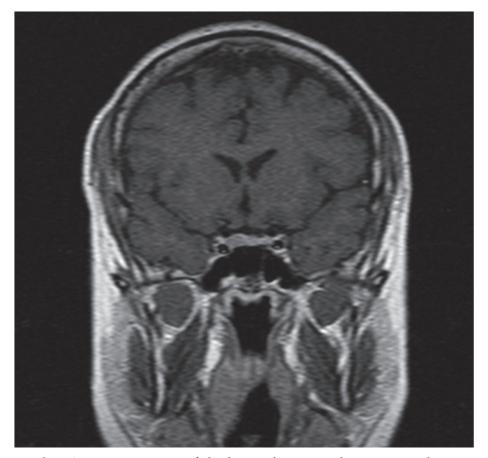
a. Coronal T1W MRI sequence of the brain showing a hypointense lesion in the right sellar area indicating a pituitary microadenoma. The patient had Cushing's disease.
